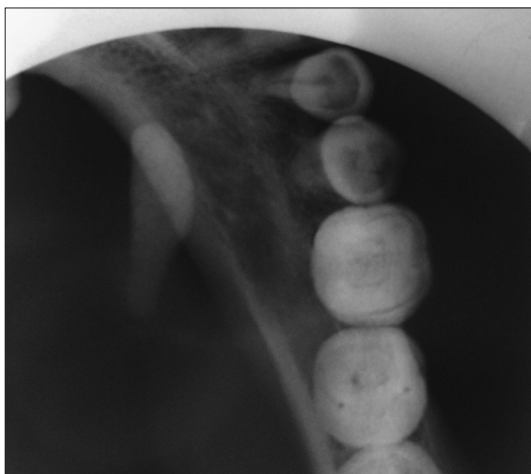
Occlusal radiograph of case 2 showing radiopaque calculus on left side of floor of mouth
